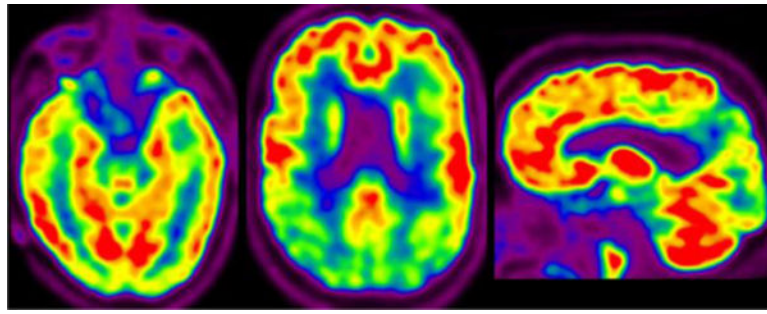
^{18}F -FDG PET in DLB. Axial images through the levels of the temporal lobes and lateral ventricles and parasagittal image show occipital and posterior temporoparietal hypometabolism. Note sparing of the posterior cingulate cortex and medial temporal lobes.
